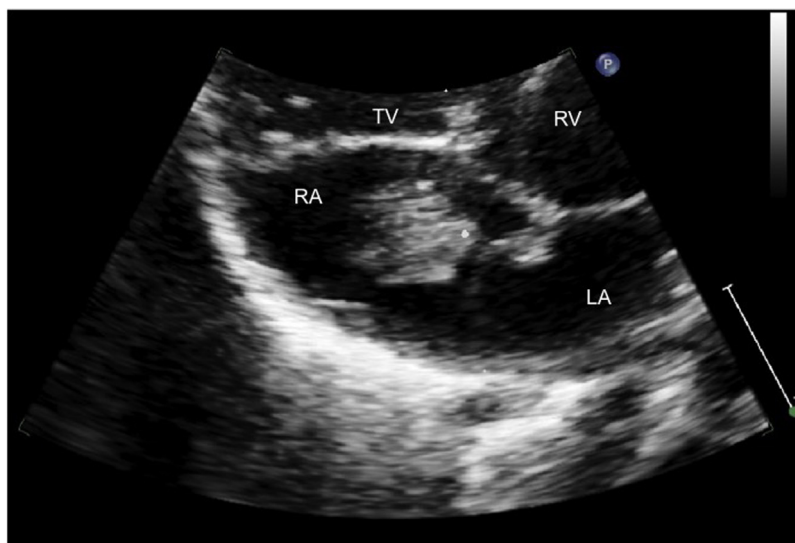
Right atrial myxoma. Echocardiogram shows a large echogenic mass filling the right atrium.
